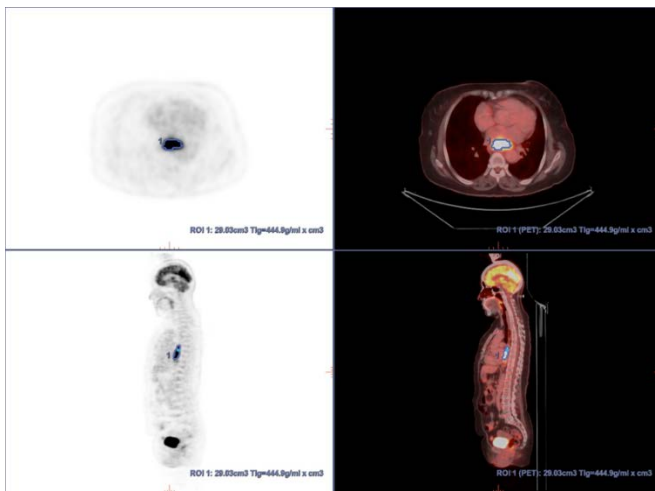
Female aged 63 years, non-survivor, survival time 338 days; no lymph node metastasis; MTV: 29.03 cm³; TLG: 444.9 g/ml.cm³; SUVmax: 19.3; NLR: 6.57; PLR: 438.5
